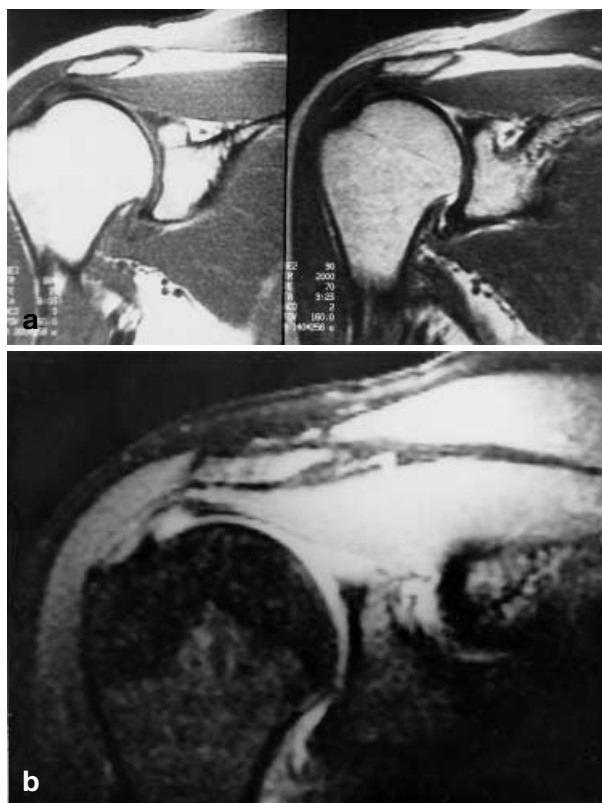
a T1-weighted (*left*) and T2-weighted (*right*) paracoronal right shoulder MR images of the patient with partial rupture. b Fat-saturated T1-weighted post-contrast paracoronal image of the same patient at the same level as a. There is discontinuity of tendon fibers in articular surface of supraspinatus muscle due to partial rupture. This is seen best in b, but is obscure on T1- and T2-weighted images
